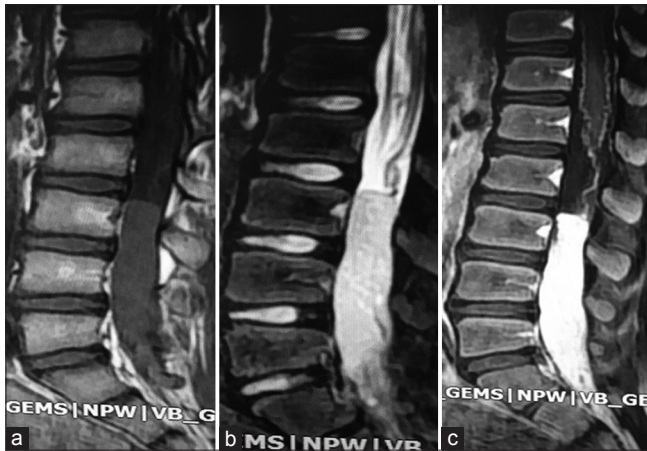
MRI showing intradural mass lesion that is isointense on sagittal T1-weighted (a), hyperintense on sagittal T2-weighted (b) and enhanced after gadolinium injection (c)
